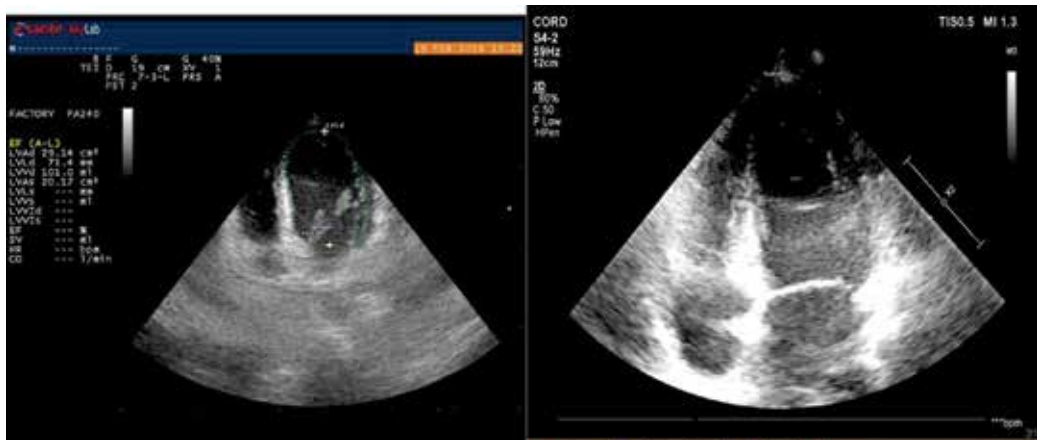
Echocardiography apical view before and after ablation of a left lateral accessory pathway with frequent episodes of antidromic tachycardia.
